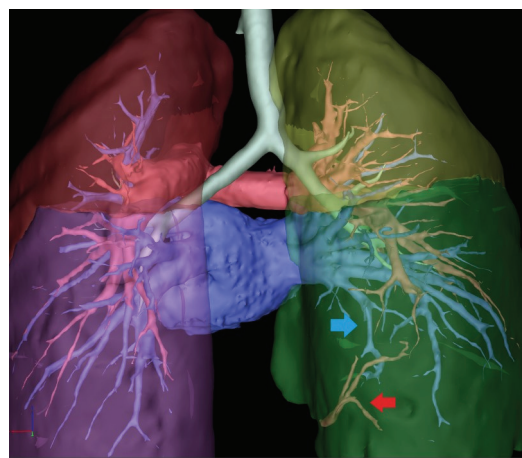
Feeding artery (red arrow) and vein (blue arrow) based on chest computed tomography.
